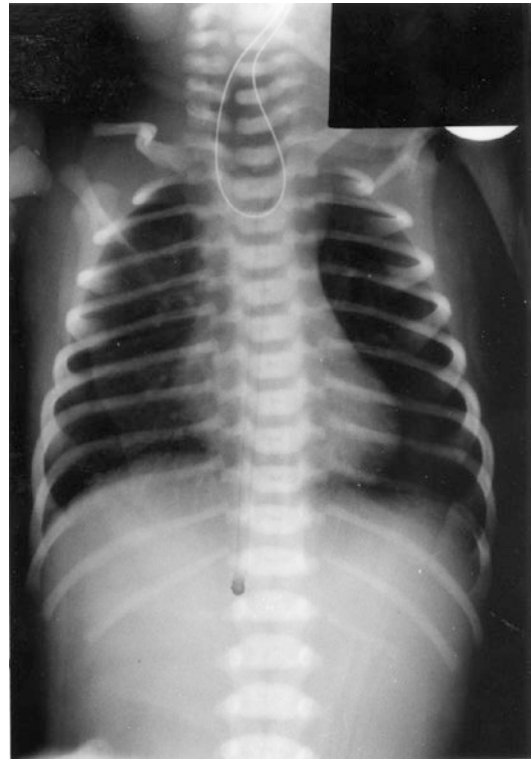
Chest radiograph of a newborn with long-gap esophageal atresia
